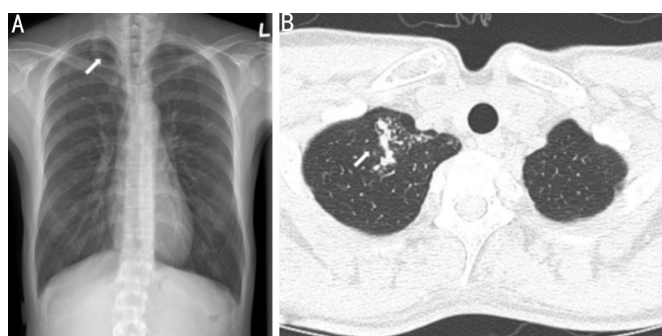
Chest radiograph showing ill-defined focal patchy consolidation in the right apex (A), and high-resolution computed tomography of the chest demonstrates multiple centrilobular nodules in the right apex (B).
